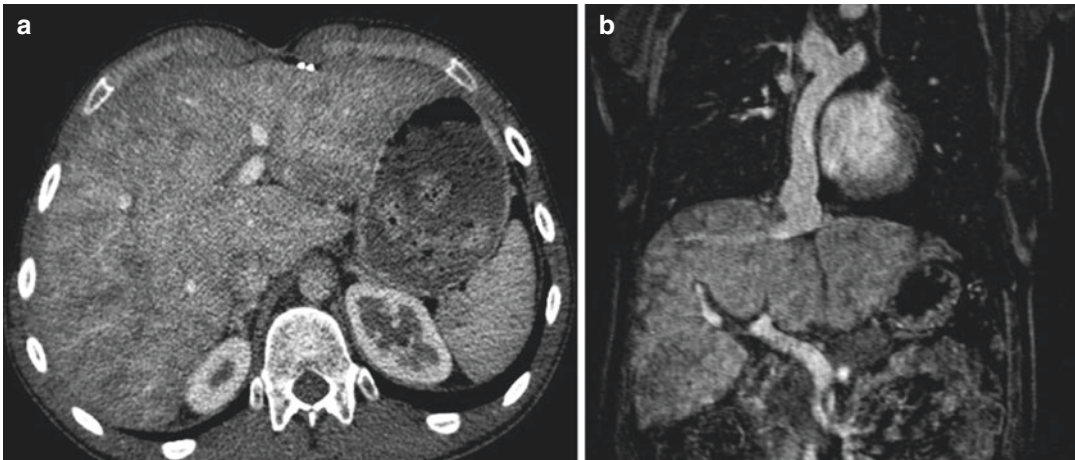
Hepatic venous congestion after Fontan procedure in two different patients. CT image (a) and portal-phase contrast-enhanced MRI (b) images show
